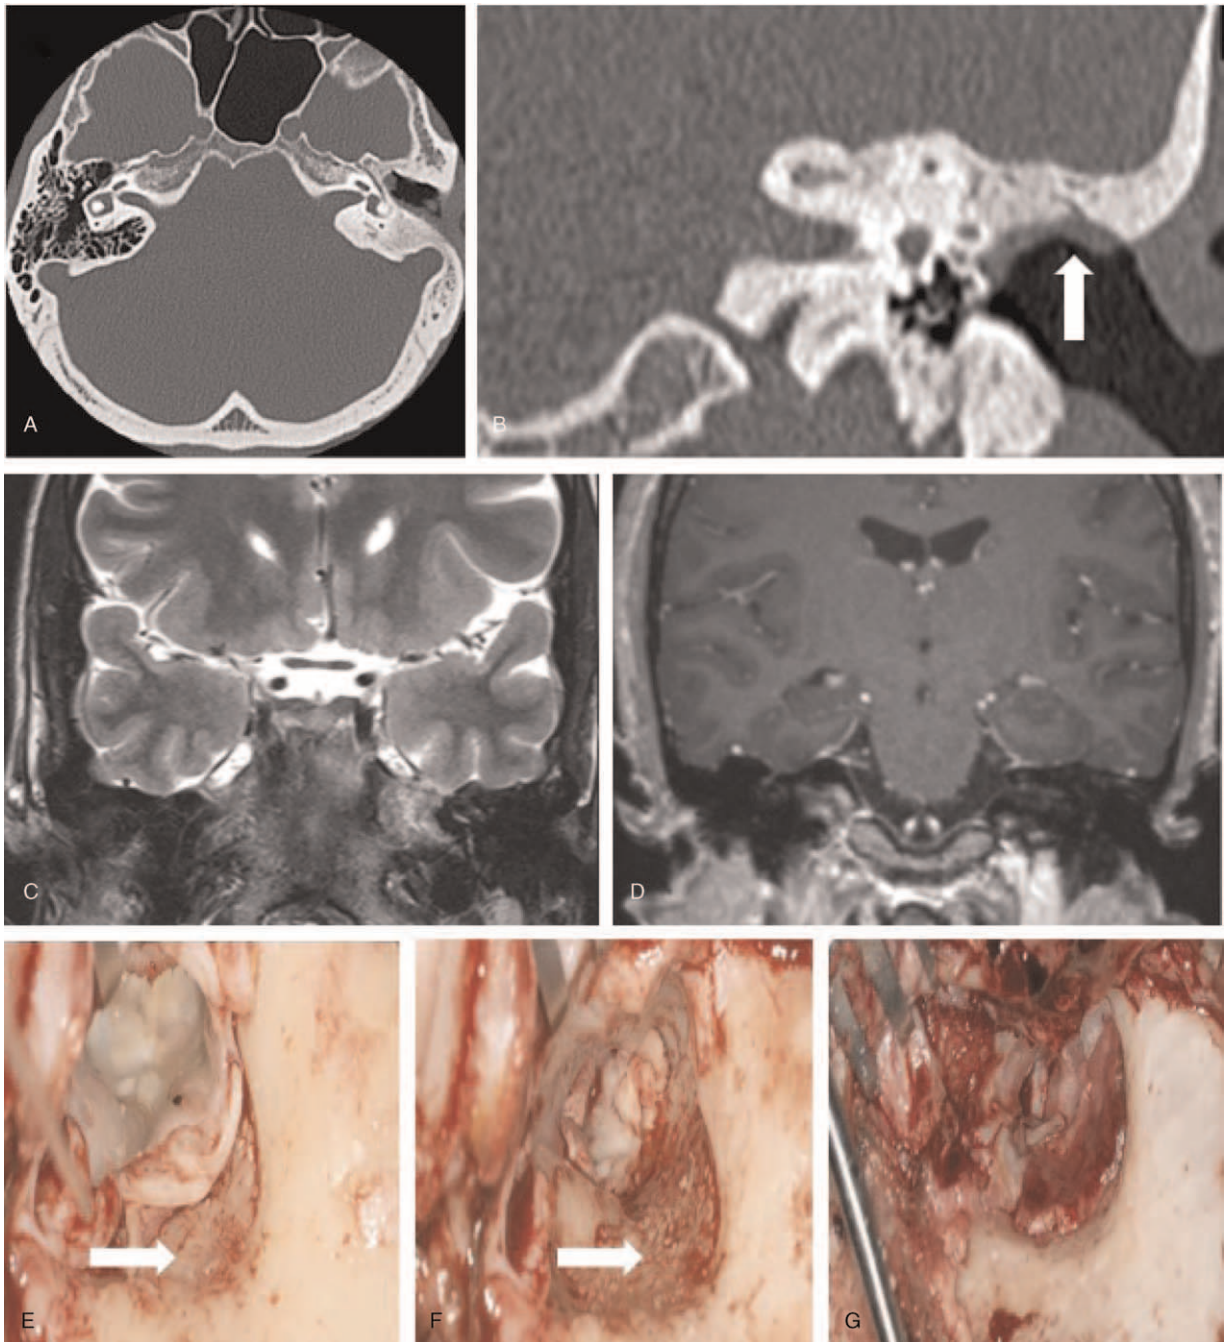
CT- and MRI-scans as well as intraoperative pictures of revision surgery of one of the patients, with the HMM still in place. *A*, CT axial view, *B*, CT coronar view, *C*, coronar MRI in T2-sequence, *D*, coronar MRI in T1-sequence. *A/B* Craniodorsally, a soft tissue formation can be seen as marked by the arrow (*B*, *C*, and *D*). The MRI shows no hints for cholesteatoma. Intraoperatively, the HMM marked by the arrow in *E* and *F* was removed and the open mastoid cavity was reduced using autologous material (*G*). CT indicates computed tomography; HMM, hydroxyapatite matrix material; MRI, magnetic resonance imaging.
